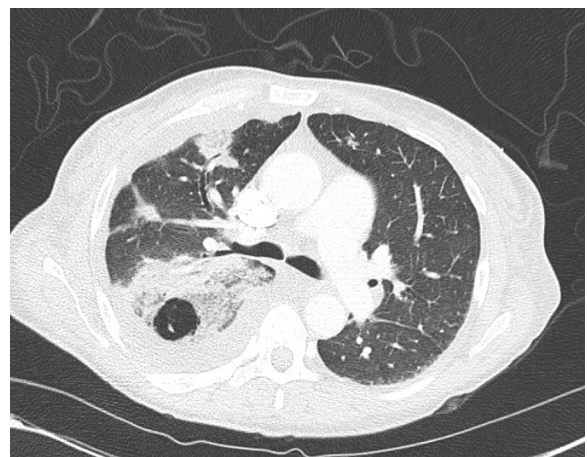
Axial section computed tomography scan of the chest with lung windows demonstrating pulmonary emboli, a cavity lesion, and pleural effusions.
